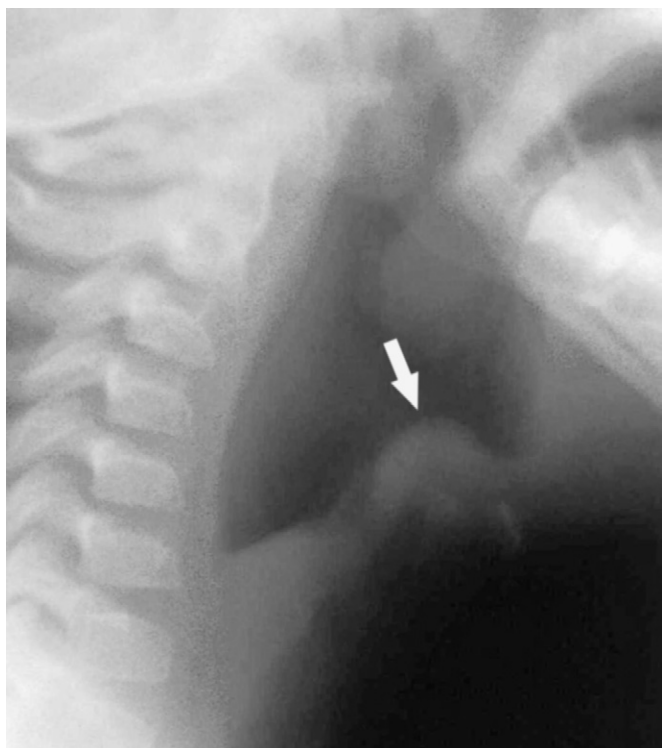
Lateral radiograph of the neck of a patient with epiglottitis. Note the large, swollen epiglottis.
